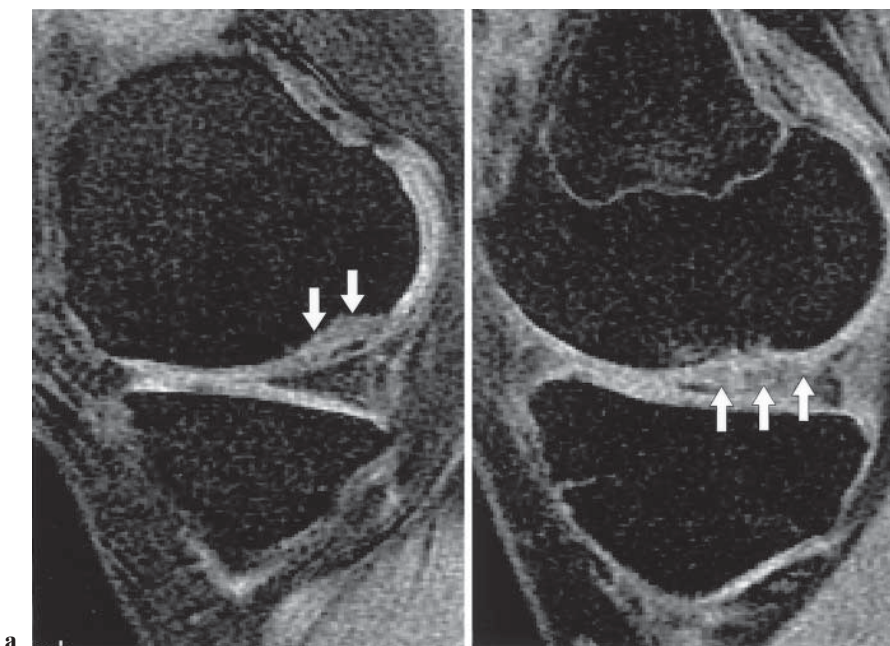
Magnetic resonance (MR) images obtained 1 year after autologous chondrocyte implantation (ACI). a Cartilage filling in the original subchondral defect was identified on three-dimensional spoiled gradient-recalled (3D-SPGR) MR imaging (arrows). b The surface of the reparative cartilage showed some irregularity and overgrowth (arrows)
